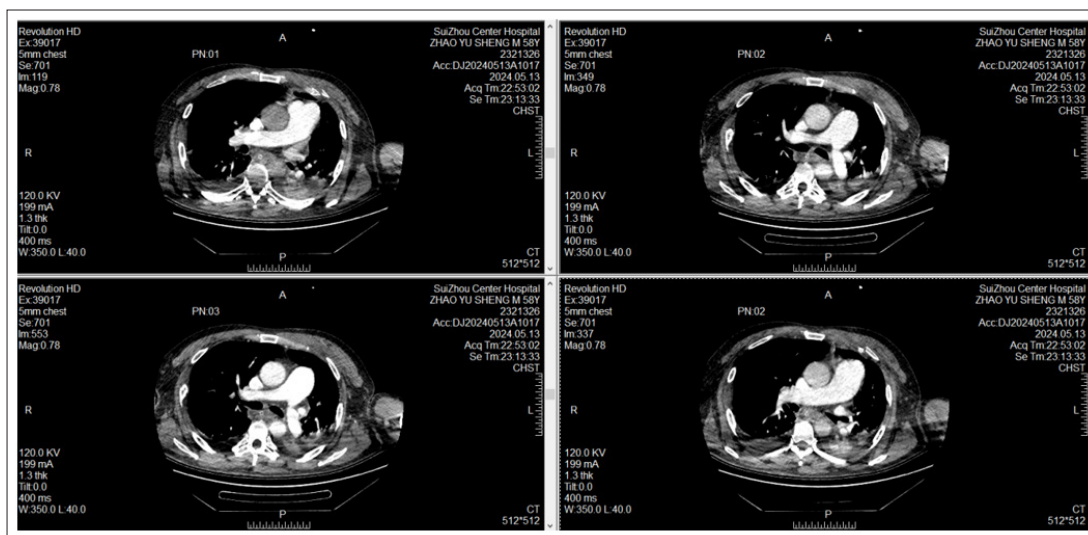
Pulmonary CTA on May 13 suggested embolism in the right upper pulmonary artery branch. Thickened main pulmonary artery (about 3.3cm). (Poor display of double pulmonary artery branches, recommended review)
